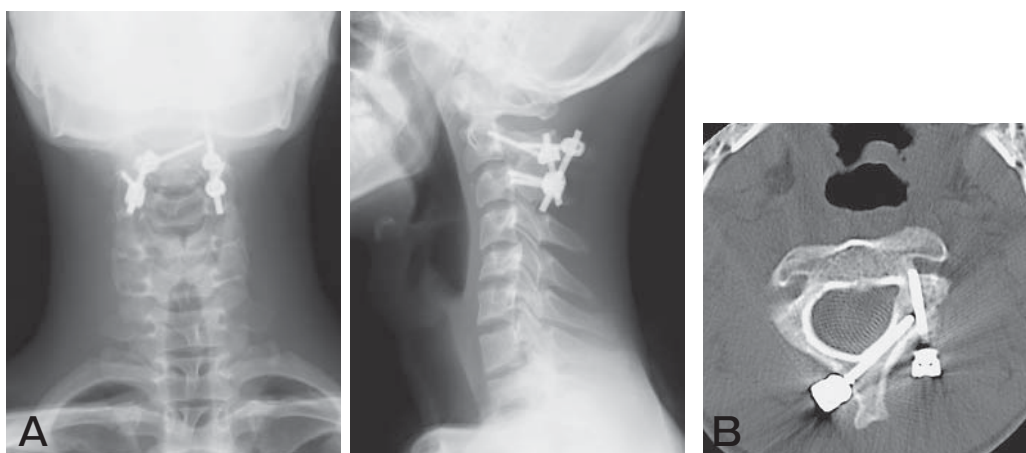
Postoperative roentgenogram and CT. A, Postoperative roentgenogram: A laminar screw was inserted into the patent side (*i.e.*, the right side of C2), and a pars screw was inserted into the occluded side (*i.e.*, the left side of C2). Lateral mass screws were inserted into both sides of C3; B, Postoperative CT shows insertion of a laminar screw.
